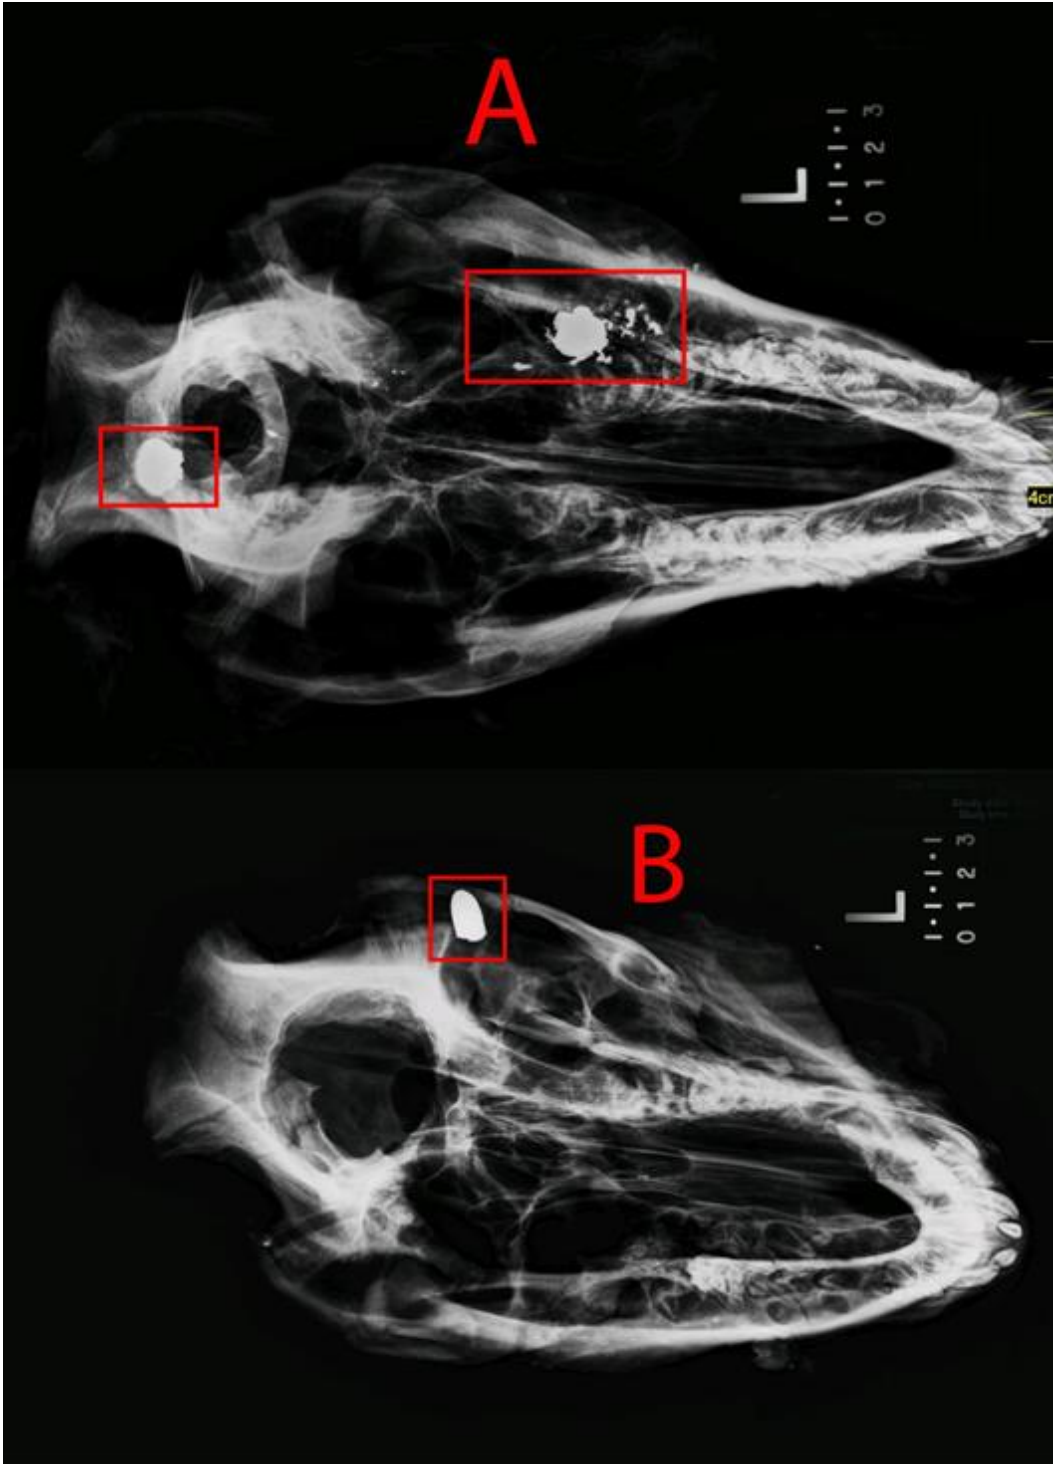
Radiographic comparison of HP and FMJ bullets. Image A (top) is an example of a Phase 2 radiograph (post-decomposition) of a hog cranium shot with hollowpoint ammunition. Image B (bottom) is an example of a Phase 2 radiograph of a hog cranium shot with full metal jacketed ammunition. Note the difference in morphology of the ROM in each image. The FMJ bullet is intact, compared to the HP bullets, which are less intact and surrounded by several ROM fragments.
